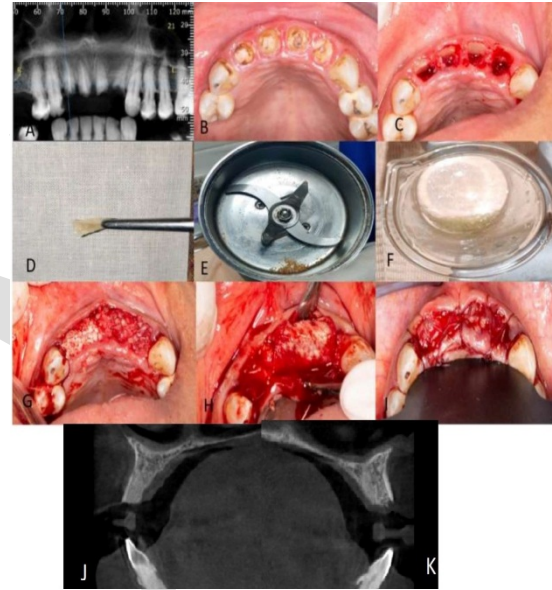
(A) Preoperative x-ray (B-C) Tooth shield preparation. (D-I) Graft preparation and placement. (J) X-ray three months post-grafting shows alloplast (TCP) behind the socket shield. (K) X-ray three months post-grafting shows autogenous Dentin Graft behind the socket shield.
